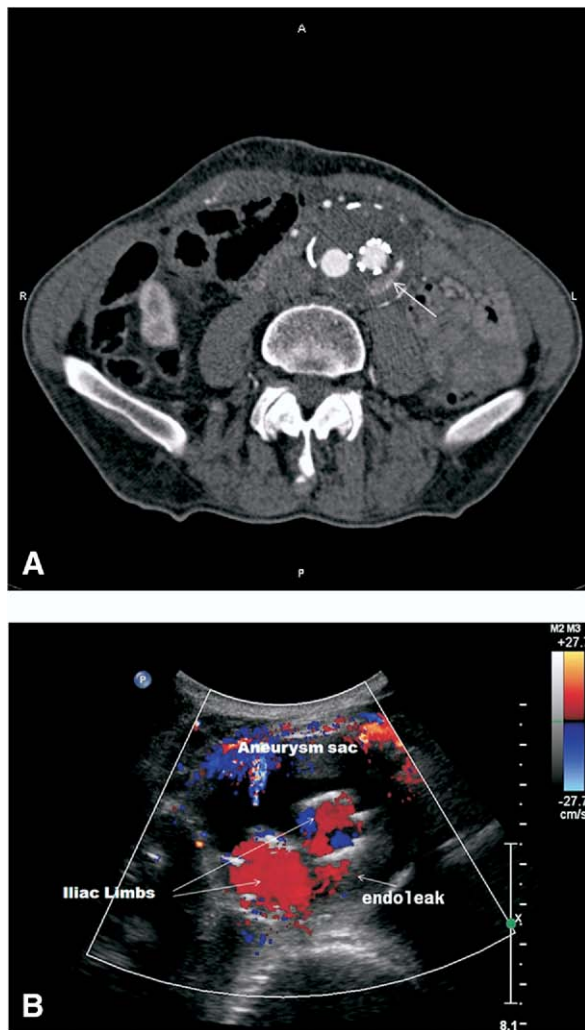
(A) An example of a type II endoleak as demonstrated on CTA. This was shown to originate from the inferior mesenteric artery, and was not associated with an increase in aneurysm sac size, and so was managed conservatively. (B) The same endoleak demonstrated on duplex ultrasonography. The iliac limbs of the bifurcated endovascular device are shown, with abnormal color flow visible in the aneurysm sac.
